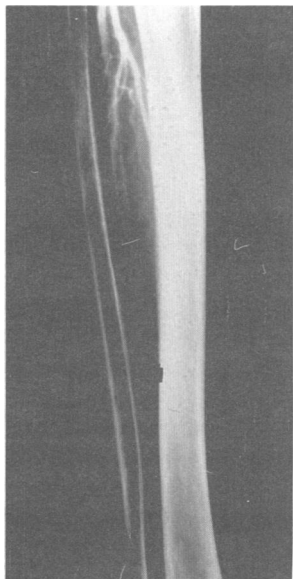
An x-ray film of the leg in a diabetic patient shows advanced arterial calcification.
